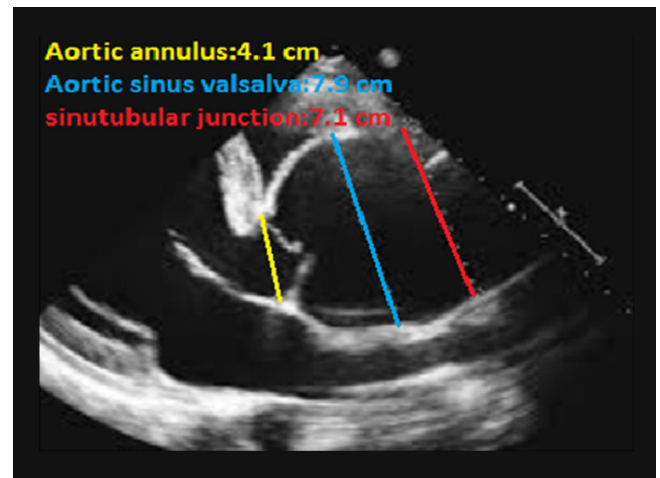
Parasternal long-axis echocardiographic view, showing a highly dilated aortic Valsalva sinus (blue line), sinotubular junction (red line), and aortic annulus (yellow line)
